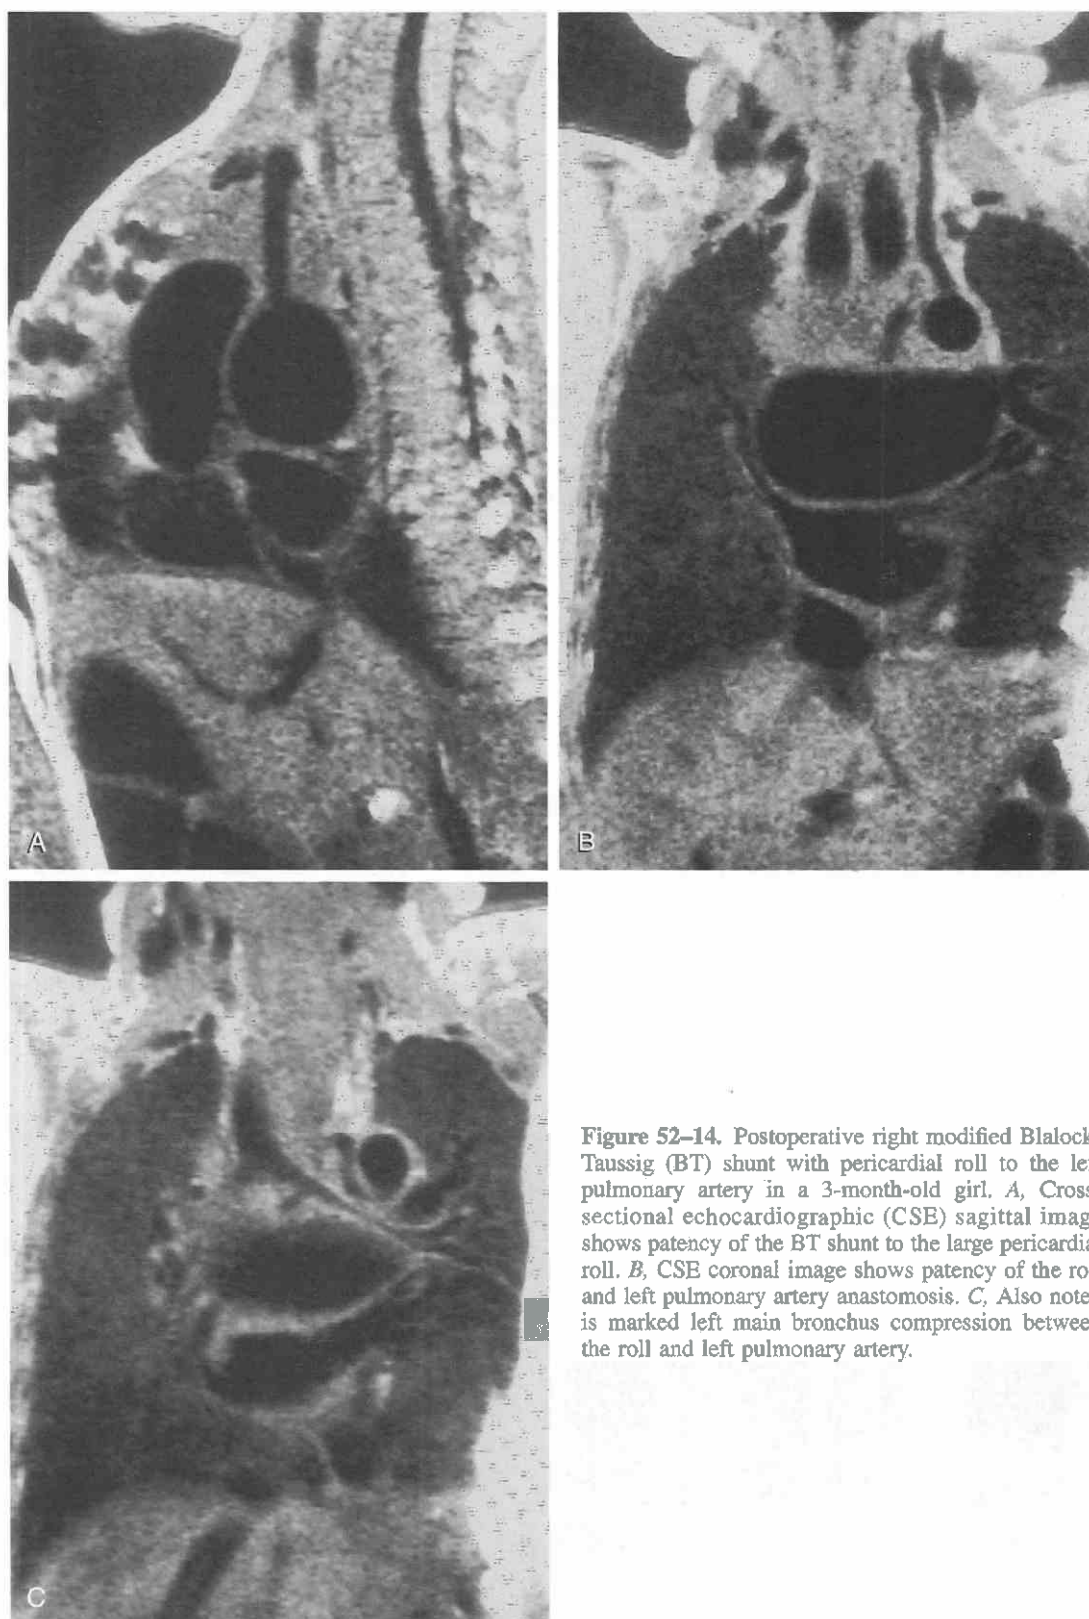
Postoperative right modified Blalock-Taussig (BT) shunt with pericardial roll to the left pulmonary artery in a 3-month-old girl. *A*, Cross-sectional echocardiographic (CSE) sagittal image shows patency of the BT shunt to the large pericardial roll. *B*, CSE coronal image shows patency of the roll and left pulmonary artery anastomosis. *C*, Also noted is marked left main bronchus compression between the roll and left pulmonary artery.
